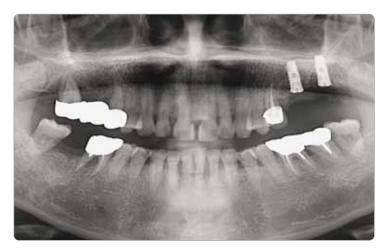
Post-op radiography
